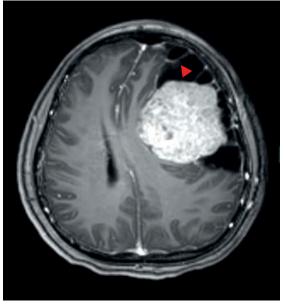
MRI: from left: (A) T2-weighted image, (B) post Gadolinium; showing a large solid-cystic mass involving left fronto-parietal region with significant mass effect. No perilesional white matter oedema or hydrocephalus (2A). Heterogenous enhancement of the solid component and multiple enhancing septae of the cystic component (2B: arrowhead) were noted.
